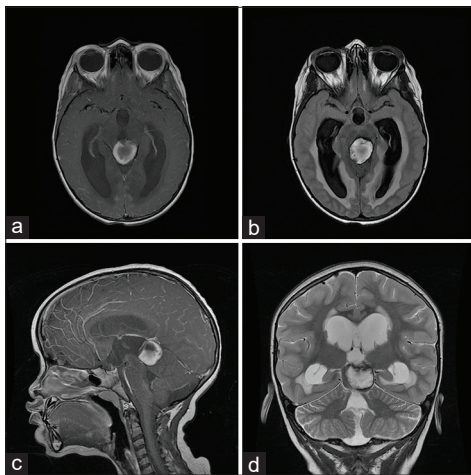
(a) Preoperative axial T1 ponderation – bleeding centered in the region of quadrigeminal lamina/pineal region associated with small round heterogeneous on his left anterior aspect with triventricular hydrocephalus, (b) axial FLAIR showing active hydrocephalus with ependymary transudation, (c) sagittal T1 gadolinium showing pineal lesion with Sylvius aqueduct obstruction, (d) T2 coronal showing pineal lesion with consequent hydrocephalus, the core of the lesion is surrounded by a halo of lower intensity due to hemosiderin.
